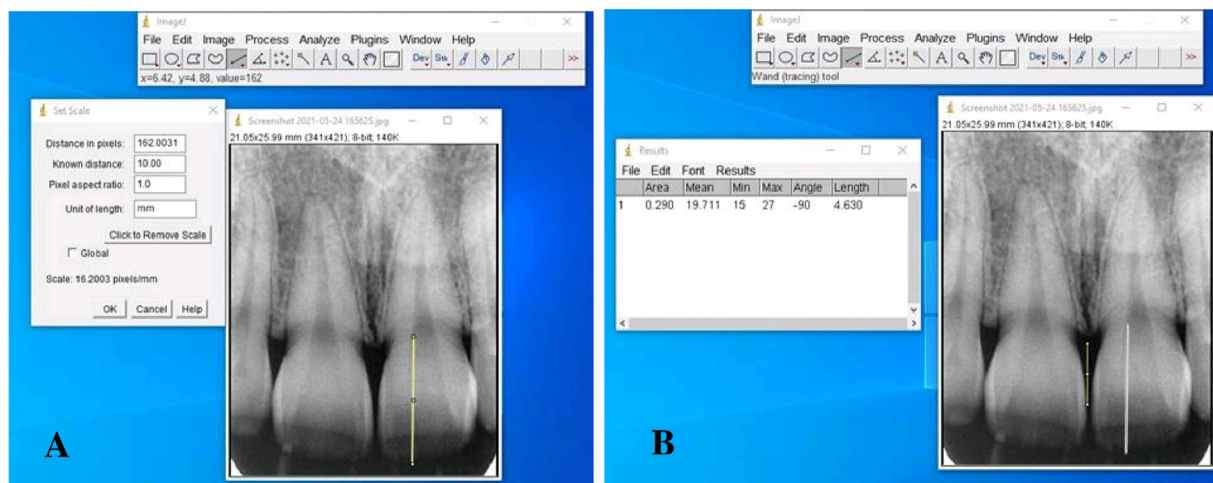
Periapical digital radiographs. (A) Calibrate the radiograph dimensions by a 10 mm metal wire. (B) Measure the distance between the apex of the alveolar process and the contact area.
